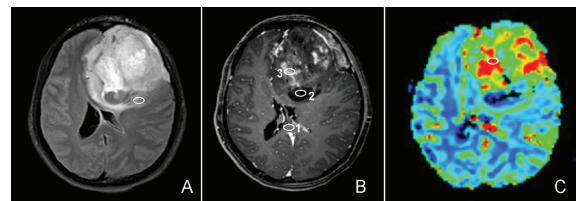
Glioblastoma. (A) FLAIR shows large left frontal lobe mass with pressure effect to the lateral ventricle. The circle is ROI for peritumoral edema region. (B) Gd-T1W shows irregular enhancement of the tumor with 1 = normal posterior corpus callosum, 2 = necrotic part, and 3 = enhancing region. (C) CBV map shows ROI of enhancing region (circle).
